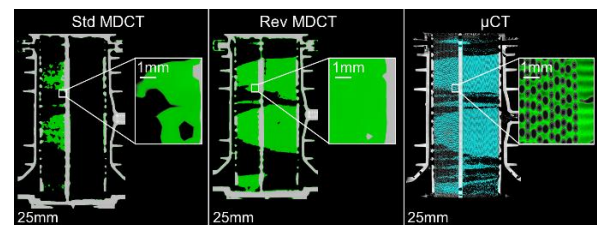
Representative cross section (std. MDCT, rev. MDCT and  $\mu$ CT) of MO 1 with segmented deposits.
